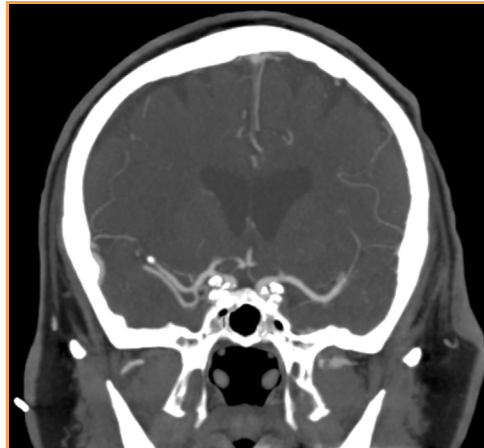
Coronal head CT angiography showing a right M2 branch calcification.
